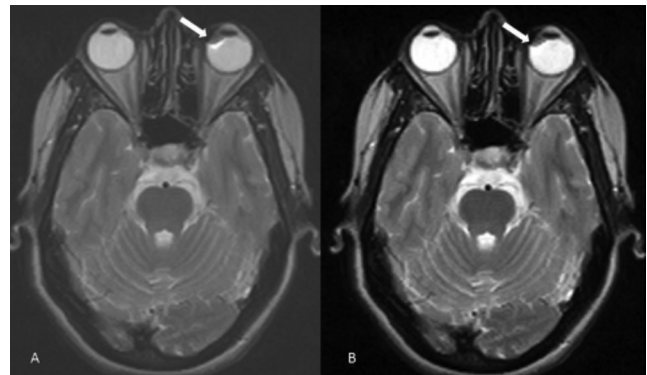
Axial T2-weighted images (A, B) show small nodular T2 hypointense lesion with a thin hyperintense border in the medial aspect of the left eyeball in the retrolental region (arrows)
